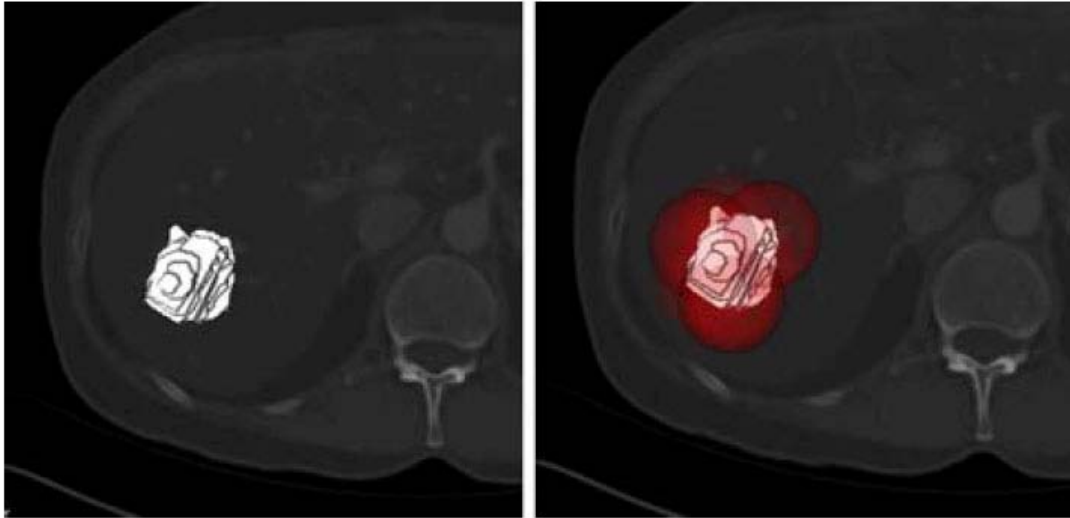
Example CT image from Georgetown University Hospital showing segmented liver tumor (white on left hand image) and overlapping sphere placement to cover tumor (red spheres on right hand image)
